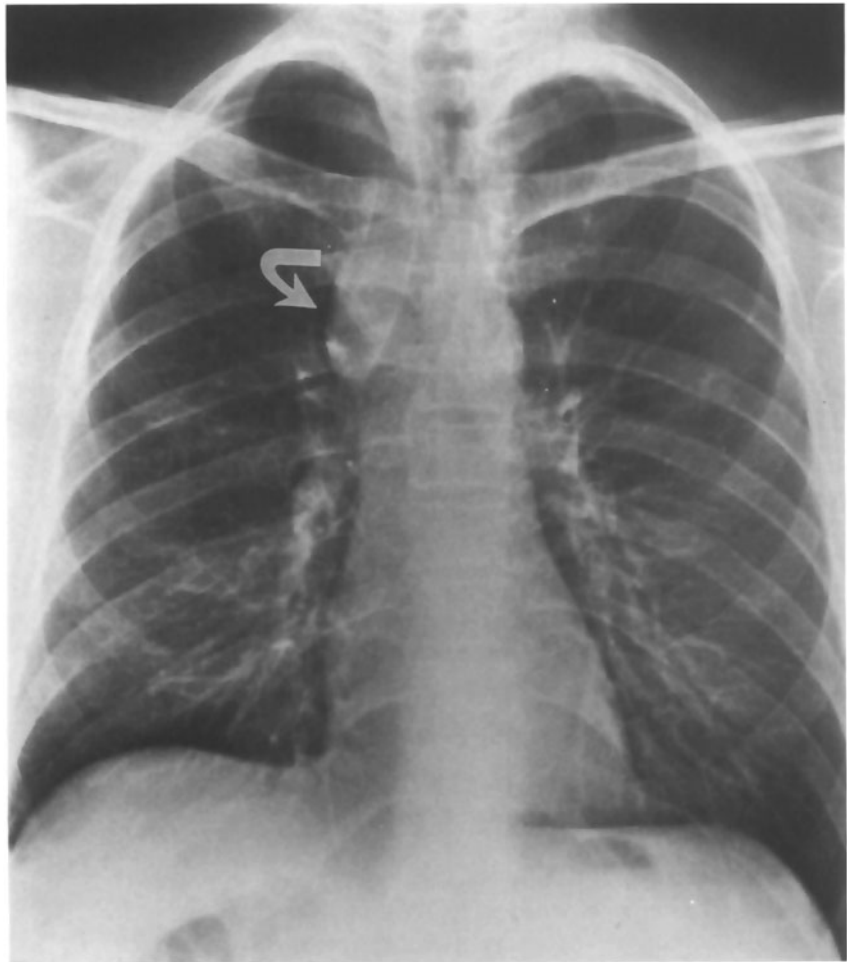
Atypical mycobacterial infection. Right-sided mediastinal adenopathy is evident in an AIDS patient with dyspnea, fever, and cough due to *Mycobacterium avium-intracellulare* infection. The adenopathy is also consistent with *M. tuberculosis* and lymphoma. On CT scan, low attenuation centers with enhancing rims of enlarged mediastinal lymph nodes favor mycobacterial infection over lymphoma.
